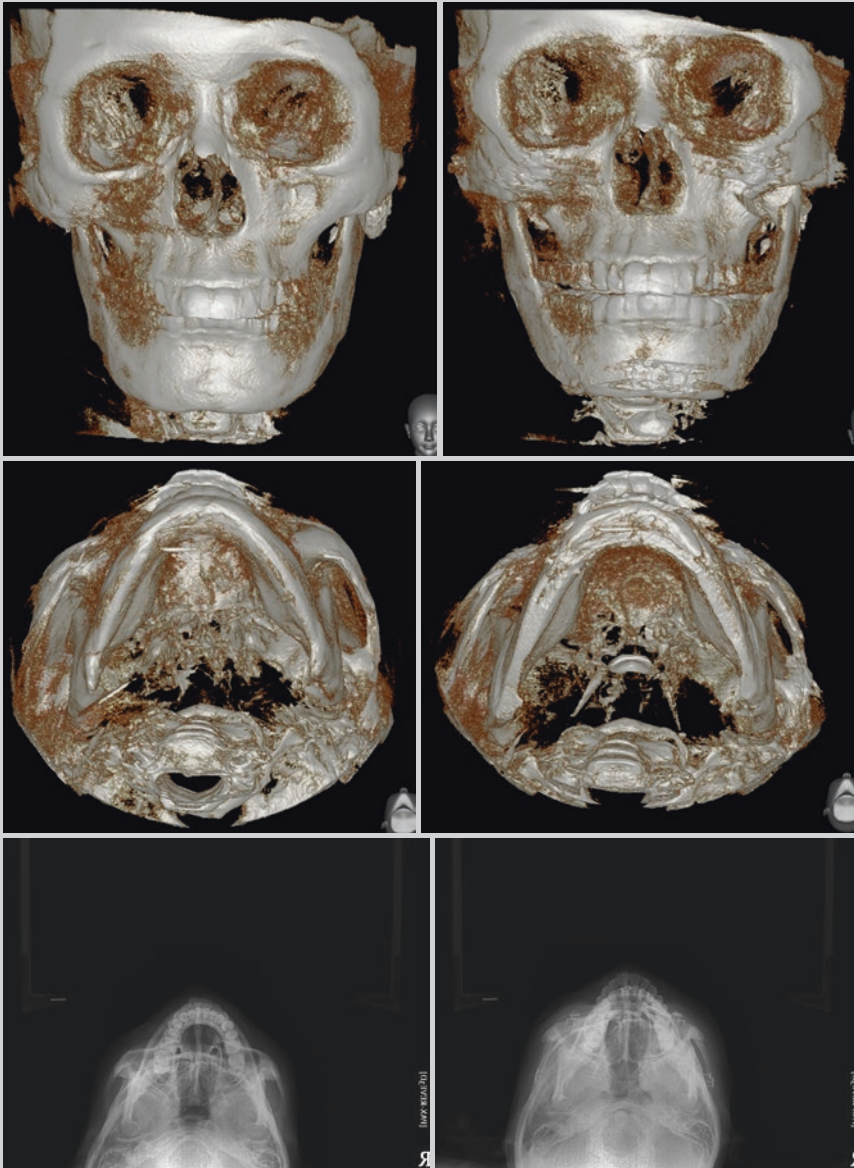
(Above and center, left) Preoperative three-dimensional CT scan. (Above and center, right) Postoperative three-dimensional CT scan. (Below, left)
